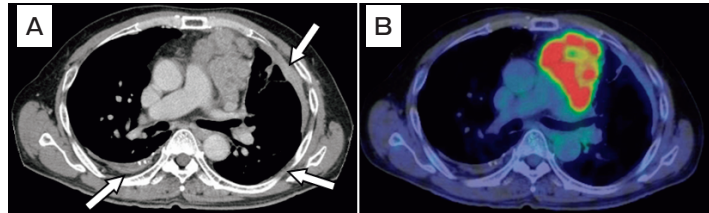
(A) A contrast-enhanced chest CT image shows a heterogeneous, enhanced anterior mediastinal mass. The white arrowheads indicate bilateral pleural thickening and plaques. (B) 18F-FDG PET/CT shows an intense uptake in the tumor (SUVmax=9.3)
